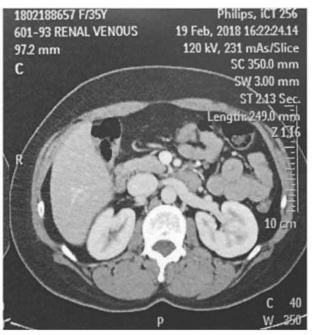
CT - scan venous phase
